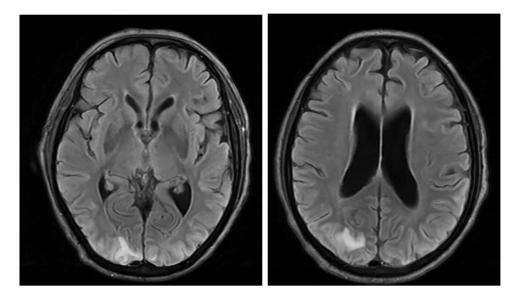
Ischemic strokes in a patient with COVID-19. MRI brain in a patient with COVID-19. DWI (left) and FLAIR (right) imaging of bilateral posterior cerebral artery strokes and a right middle cerebral artery stroke. A 64-year-old man was admitted with shortness of breath and fever. He was found to have COVID-19 infection. He was intubated on day 2 after admission and he was started on remdesivir and 0.5 mg/kg of enoxaparin daily for thromboembolic prophylaxis. He was continued on propofol and fentanyl for sedation and on day 5 to 7 after admission he was paralyzed and proned twice daily for wors-ening respiratory function. On day 12 after admission, sedation was decreased on he was noted to have left-sided weakness. A brain MRI revealed a right middle cerebral artery stroke and bilateral posterior cerebral artery strokes. He was also found to have segmental pulmonary emboli and he was started on a heparin drip.
